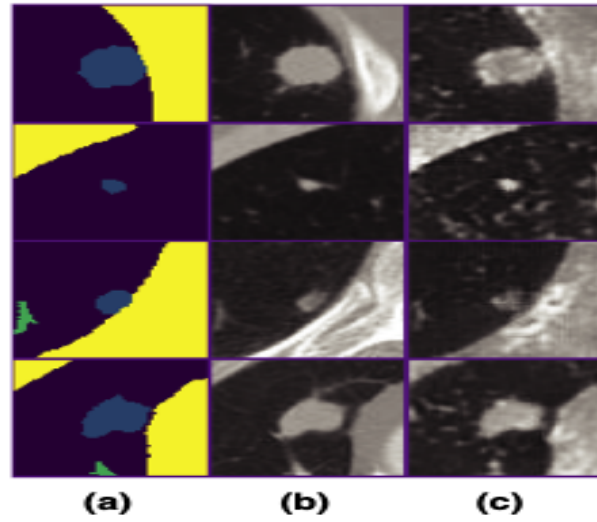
Example the synthetic generation with (a) Input Labels; (b) CT Images; (c) Images generated. From [68].
